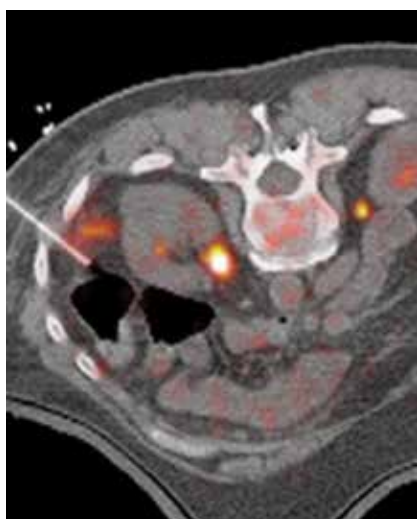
Fused PET/CT image shows placement of the hydro-displacement needle between tumor and bowel wall.
